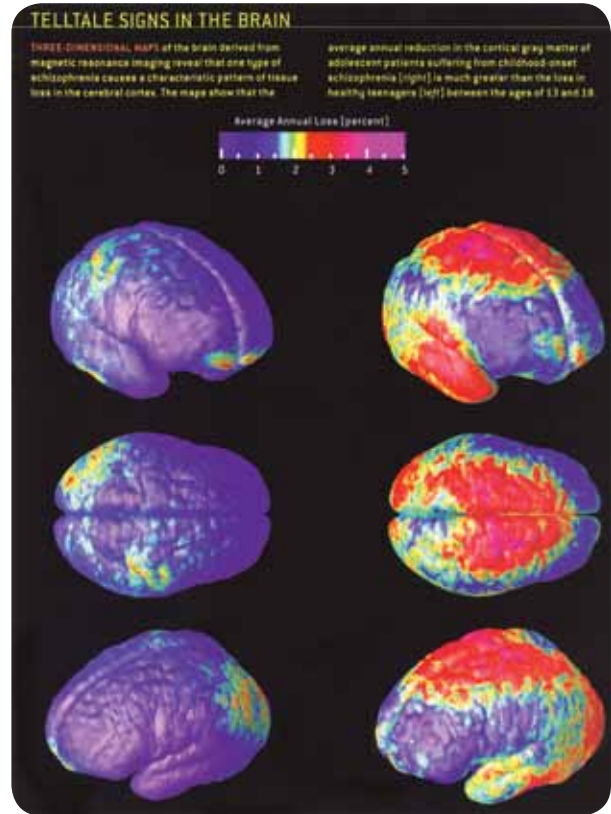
These three-dimensional images of the brain derived from MRI technology show that the average annual reduction in cortical grey matter of adolescent patients suffering from childhood-onset schizophrenia (right) is much greater than the loss in healthy teenagers (left) between the ages of 13 and 18 years.
